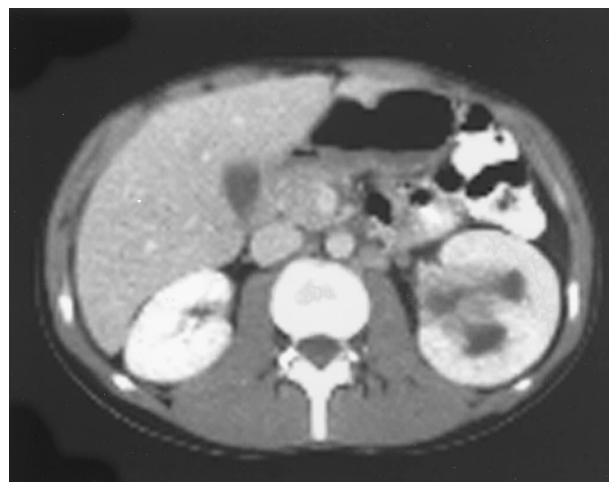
Case 3. Contrast-enhanced CT shows an infiltrative mass in the left renal hilum extending into the major calyces along the calyceal interface with the renal parenchyma, with associated hydronephrosis and delayed nephrogram.
